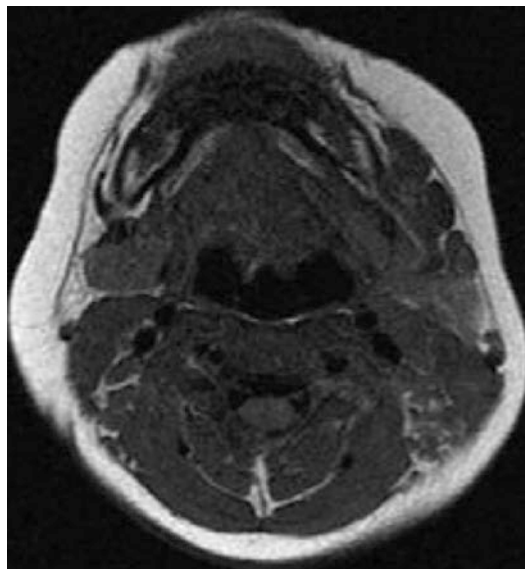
Axial T1 non-contrast MRI image of left parotid lymphatic malformation
